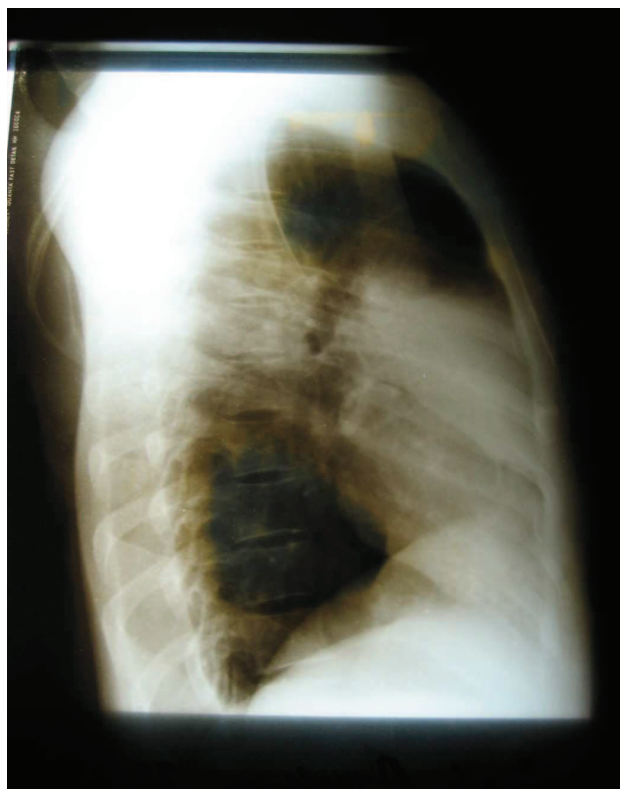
Lateral chest radiograph showing rectangular density overlying upper part of cardiac silhouette
